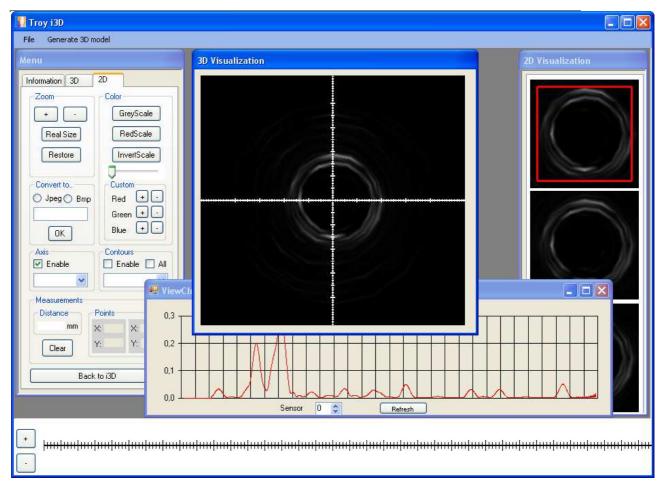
Interface of Data Analysis module based on Ultrasound raw data – 2D manipulation
